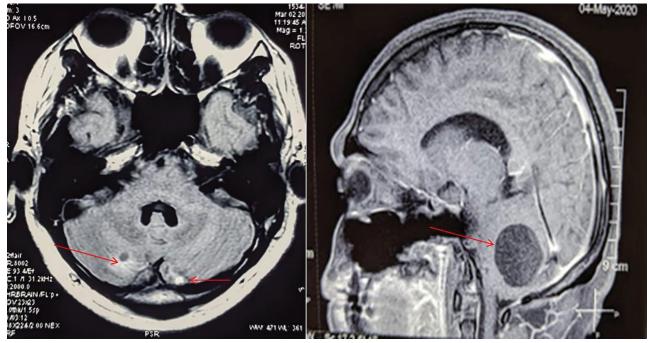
MRI brain showing bilateral hemangioblastomas
